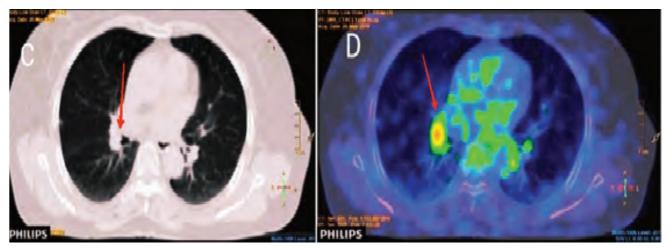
¹⁸F-FDG PET-CT scan of metastatic malignant cutaneous melanoma, CT axial image (A) showing soft tissue density nodule and fused axial view (B) showing hypermetabolic nodule in right lung. CT axial image (C) showing a 15 mm enlarged and fused axial view (D) showing hypermetabolic (SUVmax 5.4) right hilar lymph node
